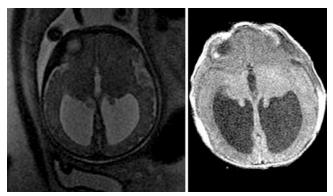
Prenatal MR image (*left*) demonstrating severe isolated ventriculomegaly (AD 23 mm). Postnatal MR image (*right*) showing no change. The patient required a ventricular shunt on DOL 25.
